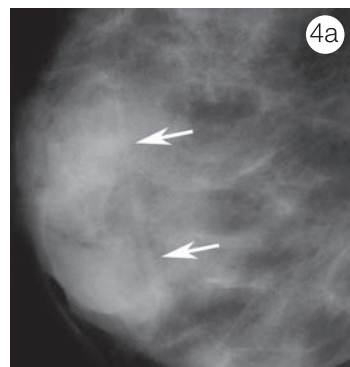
(a) Mondor disease presenting as a superficial linear density (arrows) on mammography with a corresponding to the cord-like area seen at clinical examination. (b) Ultrasound image reveals the thrombophlebitic vein.
